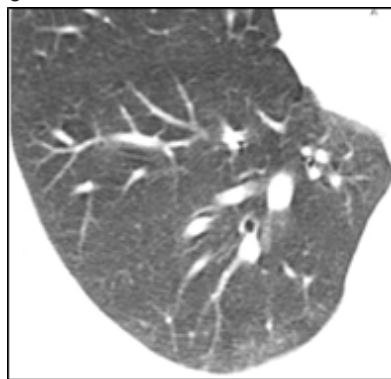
Male patient 30 years old with COVID-19. axial CT image shows subpleural ground glass opacity with prominent vessels noted in the right lower lobe. (CORADS VI and CT severity score – 4/25 -mild).
